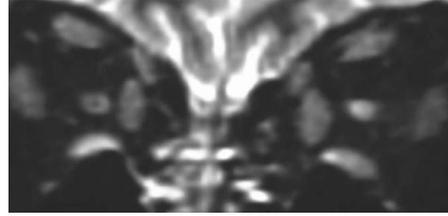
MRI of orbit, coronal T2-fat suppression images showing focal bit swollen left optic nerve with mild increased signals favoring MS-plaque.
